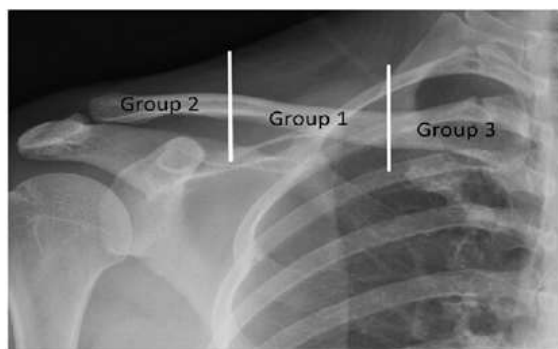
Radiograph showing clavicular fractures based on their location: 1-Middle third; 2-Lateral third; 3-Medial third.
